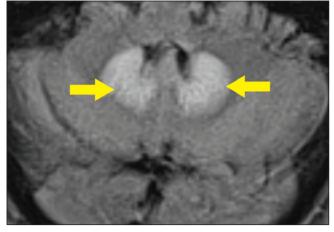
Magnetic resonance imaging shows T₂ hyperintensity of dentate nuclei bilaterally.
